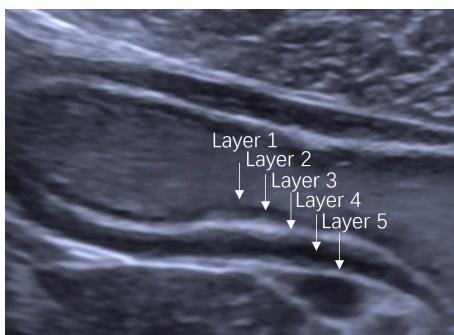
The 5-layer structure of the normal gastric wall on ultrasonography. The 5-layer structure of the normal gastric wall is numbered from the luminal side. Layer 1 is the interface echo between the gastric lumen and the mucosa, layer 2 is the rest of the mucosa, layer 3 is the submucosa, layer 4 is the muscularis propria, and layer 5 is the serosa.
